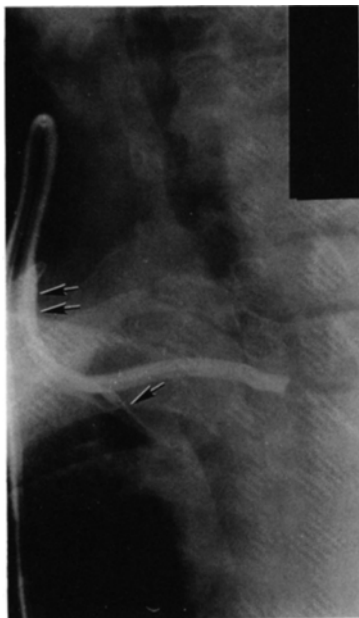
Radiograph obtained following bolus contrast injection through the large catheter lumen. No flow is evident from the catheter tip, but retrograde tracking of contrast is seen along the superior aspect of the catheter (adjacent arrows). The distal catheter is surrounded by a fibrin sleeve, with flow emerging at the site identified on the earlier radionuclide studies (single arrow).
